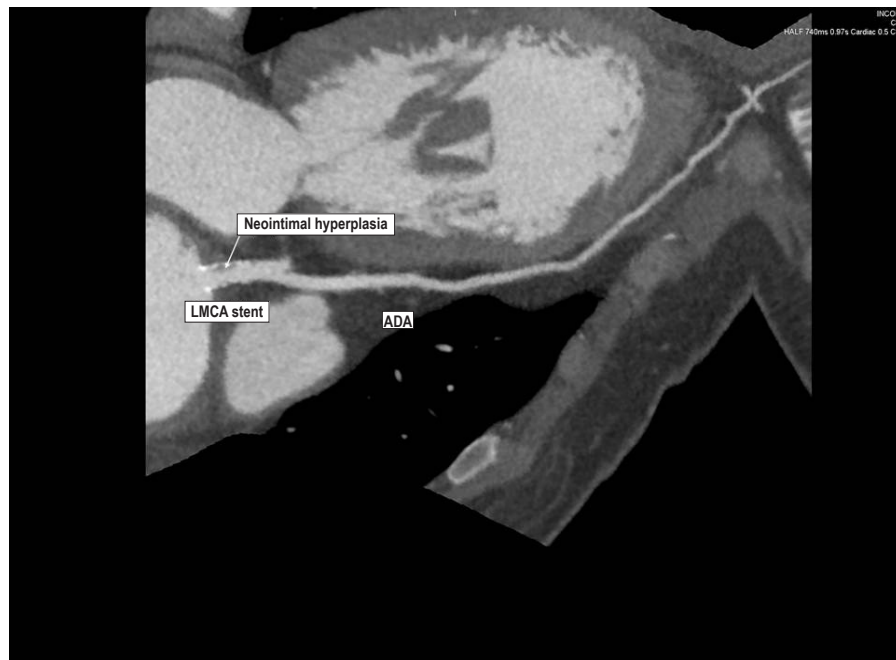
Coronary CT angiography showing bare-metal stent restenosis in the left main coronary artery (70% obstruction). LMCA : left main coronary artery; ADA : anterior descending artery.
